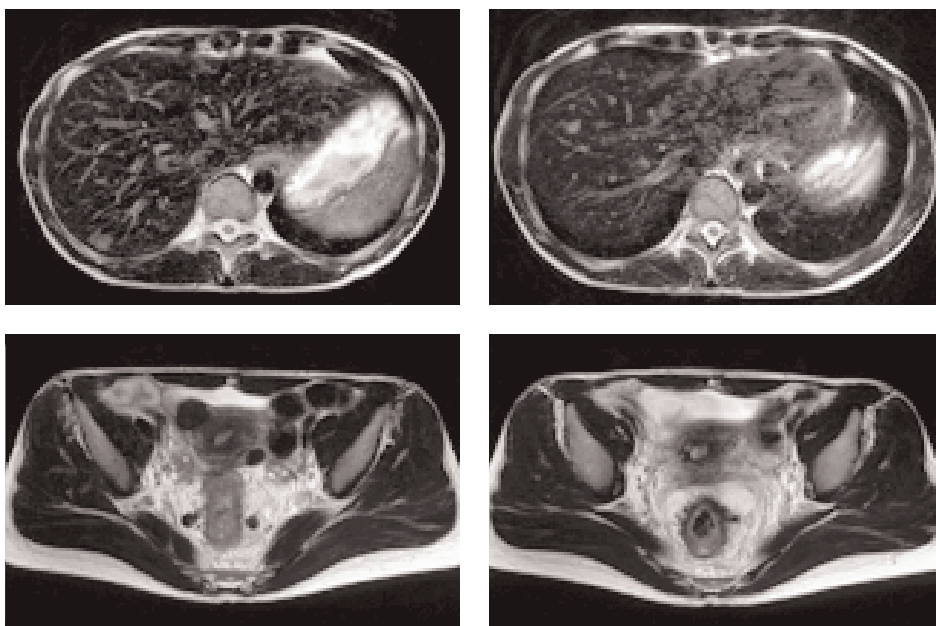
SPIO T2-weighted image.
